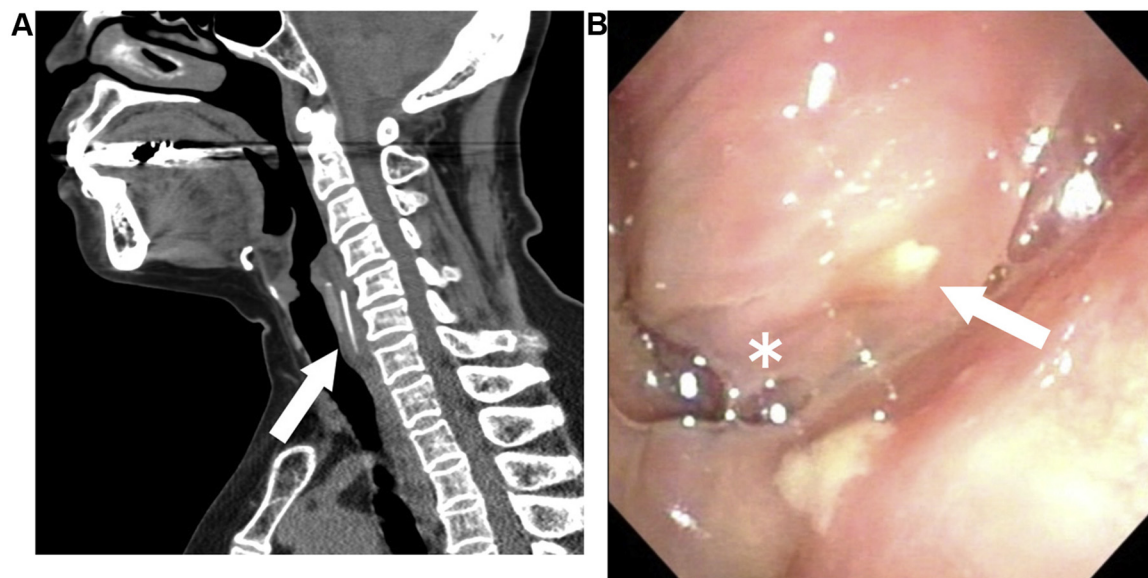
(A) Sagittal CT shows the fish bone vertically in the posterior wall of the hypopharynx or intraluminally (arrow). (B) Intraoperative view of the hypopharynx. A white object buried in the dorsal side of the right arytenoid is seen (arrow). White fur is also seen in the posterior wall of the hypopharynx. *, post cricoid lesion.
